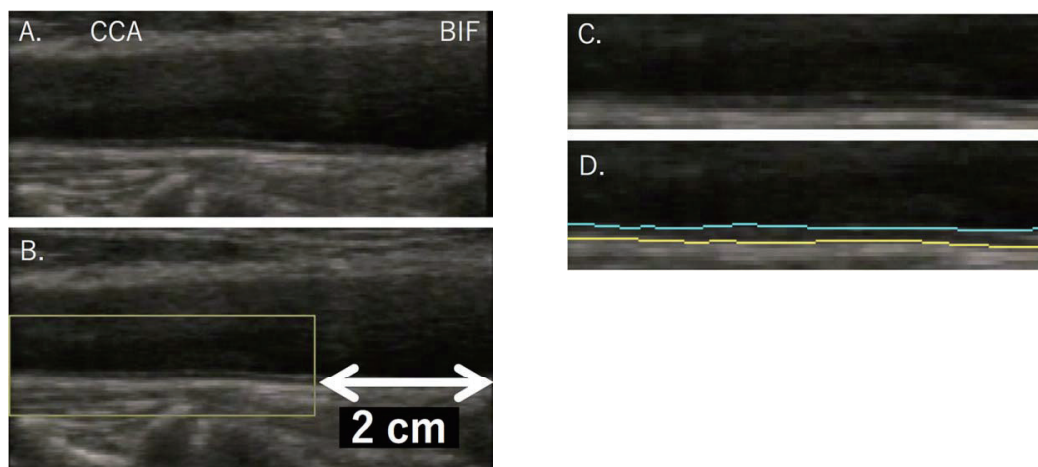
B-mode ultrasound image sample of the CCA showing the measurement of IMT by IntimaScope
